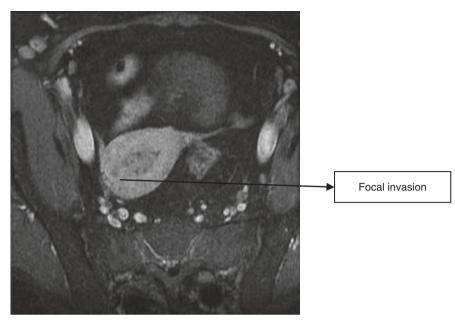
MRI showing superficial myometrial invasion
